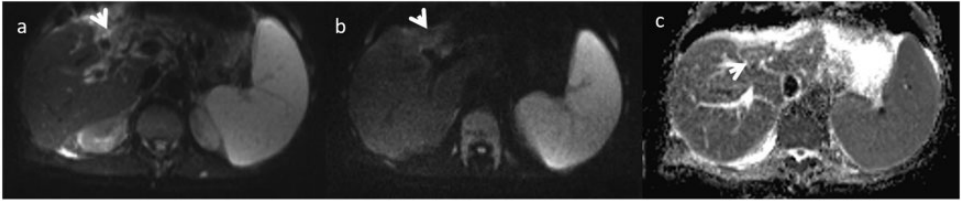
Same patient as in Figure 7. DWI sequences: (a) b value = 50 s/mm², (b) b value = 800 s/mm², and (c) ADC map. The lesion showed a restricted signal (arrow) with isointense signal on ADC map (arrow).
